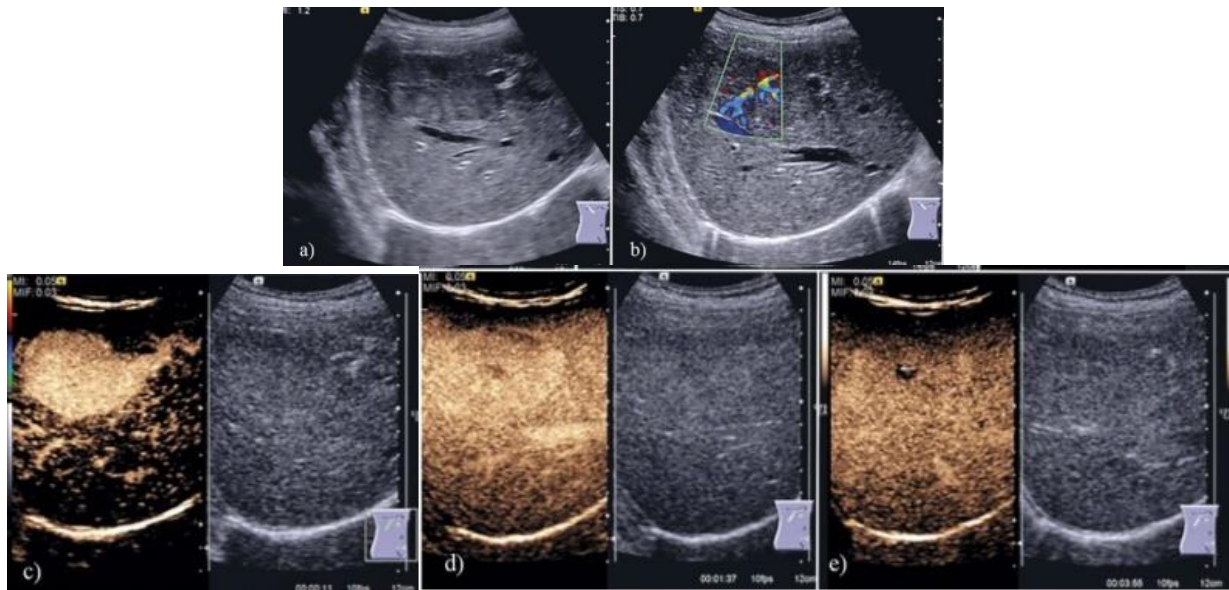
a) Slightly hypoechoic focal liver lesion in the right liver lobe. b) The lesion shows “spoke-wheel” pattern on Doppler US. c) CEUS, arterial phase – the lesion is completely hyperenhanced 11 seconds after bolus injection – excentric feeding artery also visible. d) CEUS, portal phase – the lesion is slightly hyperenhancing with visible central scar. e) CEUS, late phase – the lesion is iso/hyperenhancing with well visible central scar.
